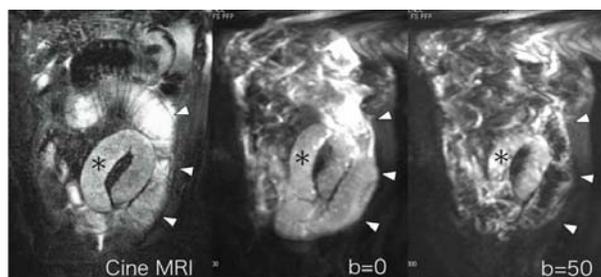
A 65 year old man with strangulated SBO. Cine MRI and SS-EPI image (b=0) image cannot visualize the strangulated loop (*) selectively. On low b-value (b=50 sec/mm²) image, the strangulated loop is highlighted thanks to signal suppression of the dilated oral loop (arrowheads) with normal peristalsis function.
